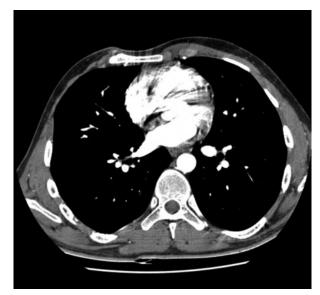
Conventional CT scan reveals absent pectoralis major muscle, absent ribs and extremely thinned soft tissue separating skin and pleural cavity at the right side
